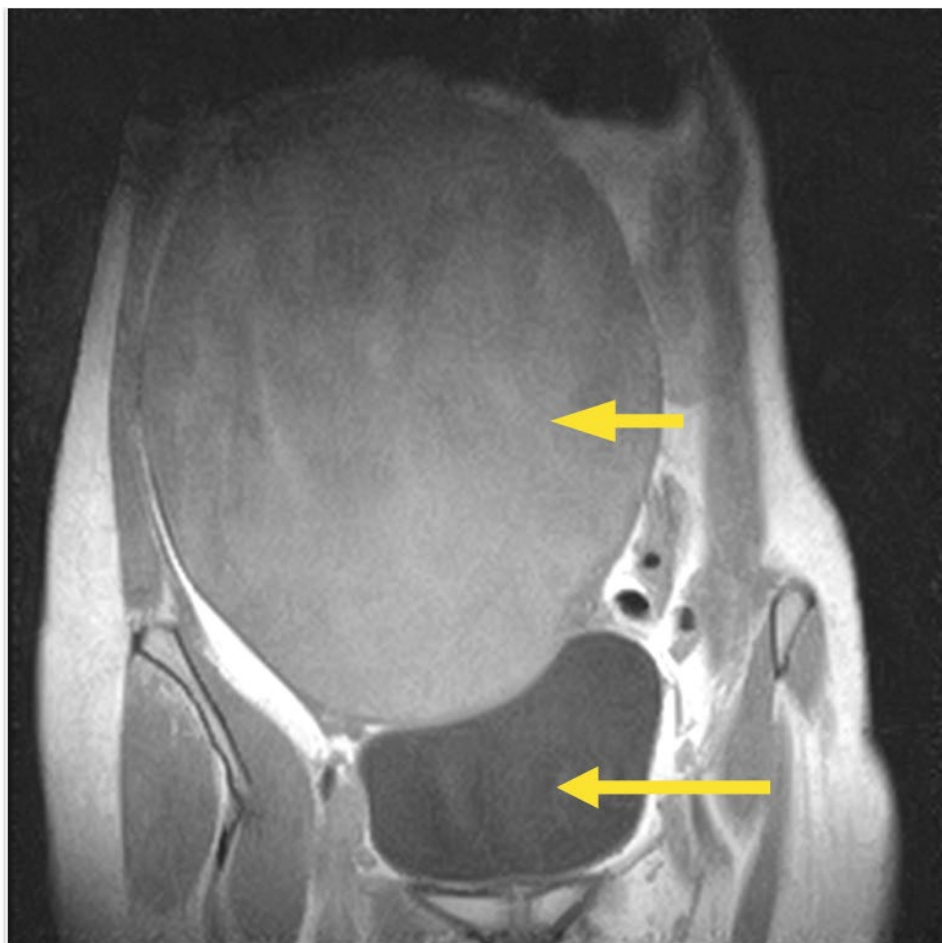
MRI image of the cystic lesion- T1 cor image.
